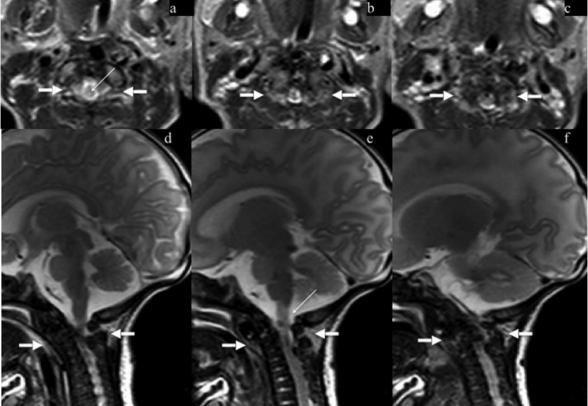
Transverse and sagittal T2-weighted images show dysmorphic craniocervical junction, spinal cord compression (thick arrows) and increased cord signal intensity in keeping with myelomalacia (thin arrows).
